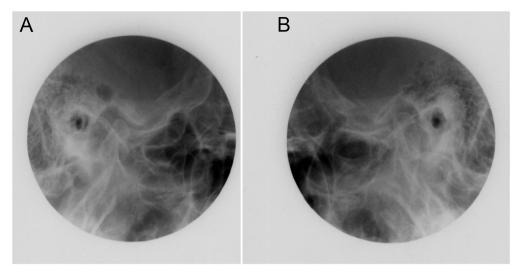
Radiographs of Schüller projection: (A) right side, (B) left side.
